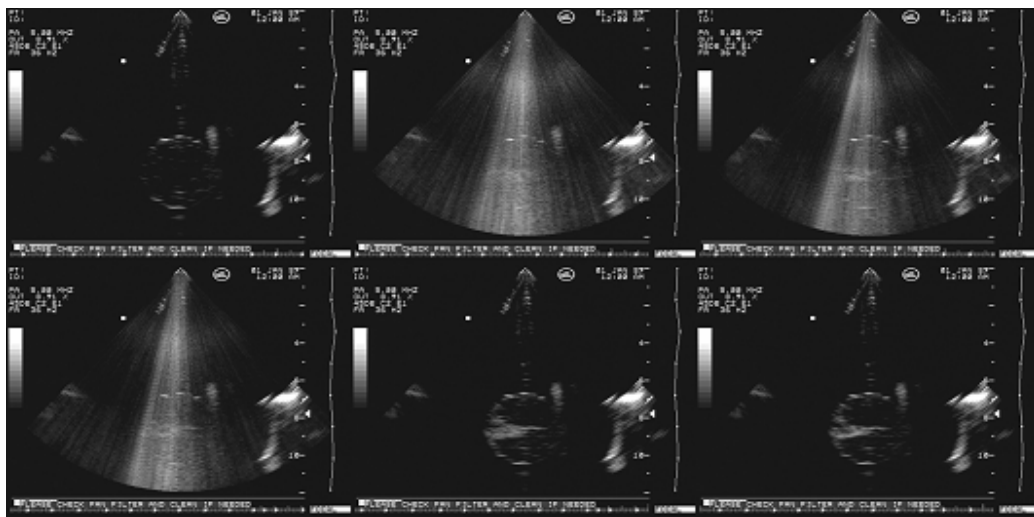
PLA microbubbles excited by an ultrasonic pulse of 500 mVpp.
